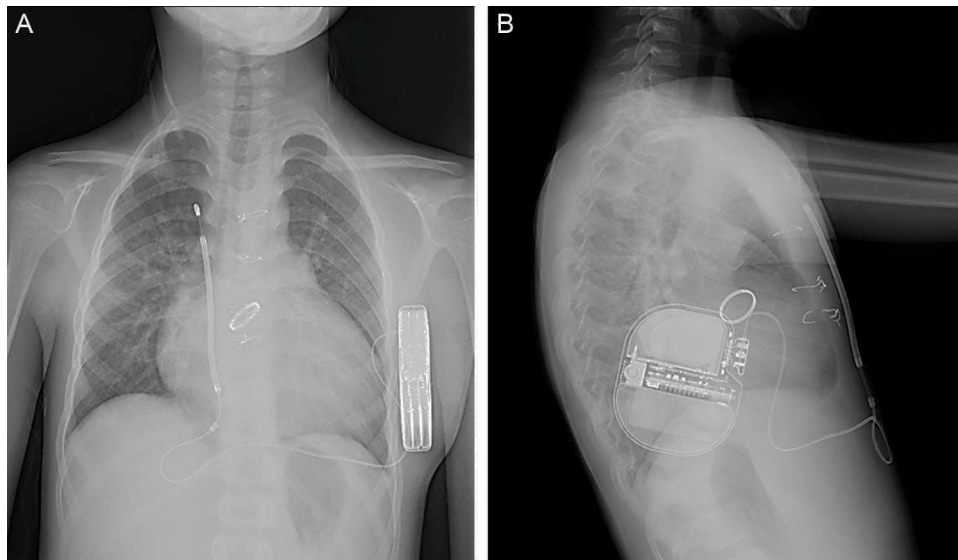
Posterior-anterior (A) and lateral (B) chest X-ray of the implanted device in the patient.
